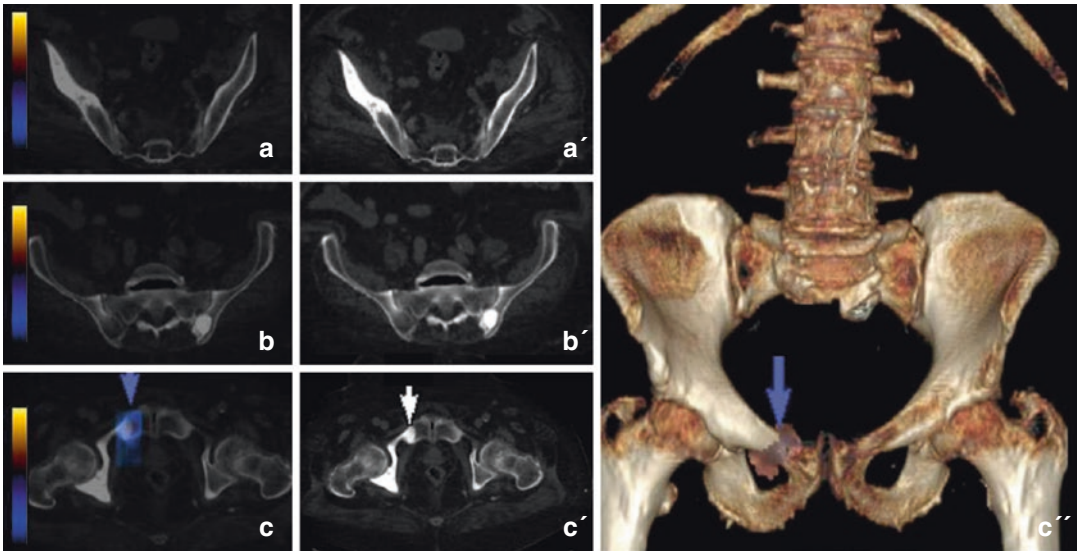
Axial PET/CT views showing sclerotic lesions of the pelvis without significant ^{18}F -FMC uptake (a, a', b, b'), in a patient with prostate cancer undergoing hormonal therapy (PSA 33 ng/mL at the time of the scan). Only a
